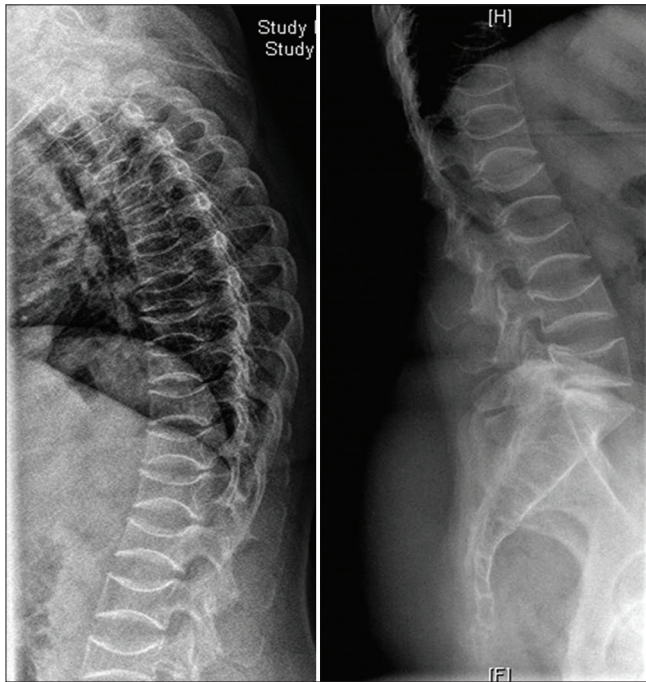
X-ray of the thoracolumbar spine (left) and lumbosacral spine (right) showing multiple vertebral compression fractures
